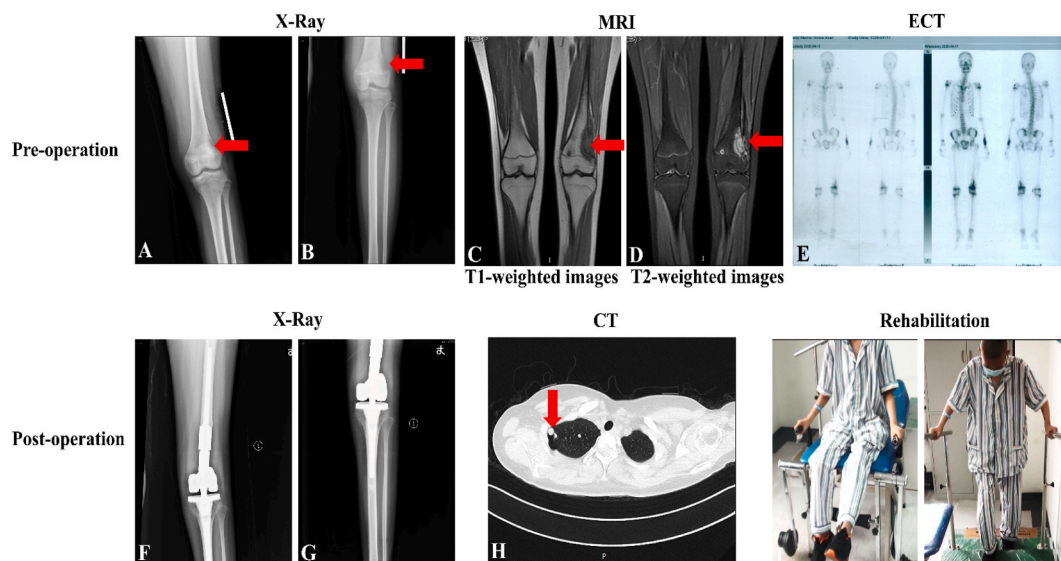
Pre- and post-operative imaging and rehabilitation. (A) Pre-operative X-Ray of knee lesion (red arrow). (B) Pre-operative X-Ray of tibia lesion (red arrow). (C) Pre-operative MRI T1-weighted image showing the lesion (red arrow). (D) Pre-operative MRI T2-weighted image showing the lesion (red arrow). (E) Pre-operative ECT scan indicating bone activity. (F) Post-operative X-Ray showing knee implant. (G) Post-operative X-Ray showing tibia implant. (H) Post-operative CT scan of chest (red arrow). (I) Rehabilitation process during physical therapy.
